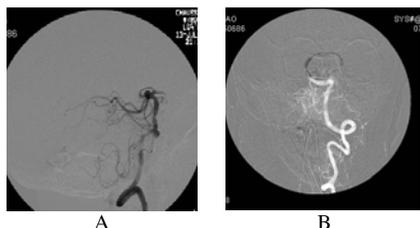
X-ray angiogram showing occlusion (A) and after balloon angioplasty (B) to remove the occlusion which benefited from a non-invasive assessment of brain physiology while the balloon was inflated during the procedure to look for undesired regions of abnormal cerebral blood volume (CBV) in a PWI scan, as well regions of ischemia, with DWI due to the arterial occlusion (Figure 1). The physiological information available from the MR also guided improved balloon sizing and placement.
